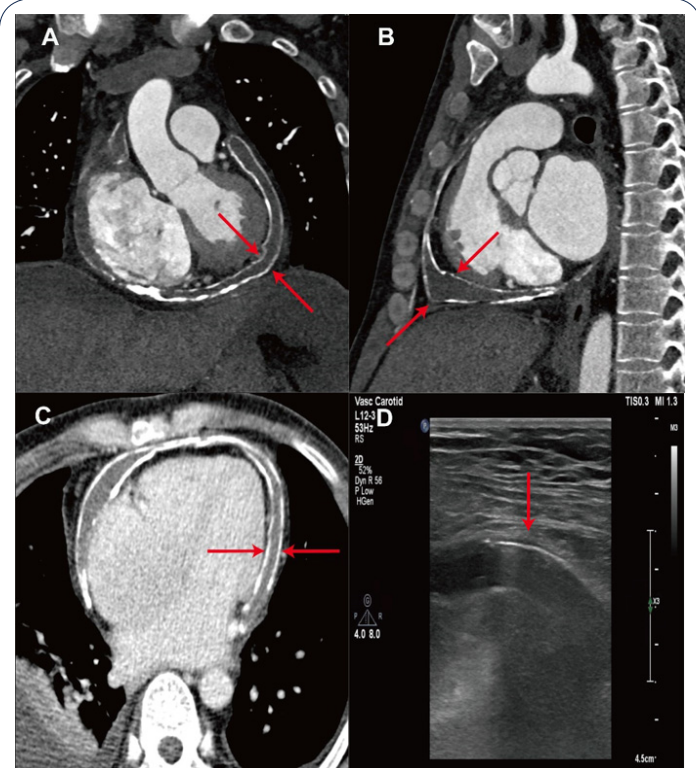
Thickened and circumferential calcification of both the parietal and visceral layer pericardium were observed at coronary (A), sagittal (B), and transverse plane (C) on cardiac computed tomography. The distinctly thickened pericardium was confirmed by transthoracic echocardiogram (D).
